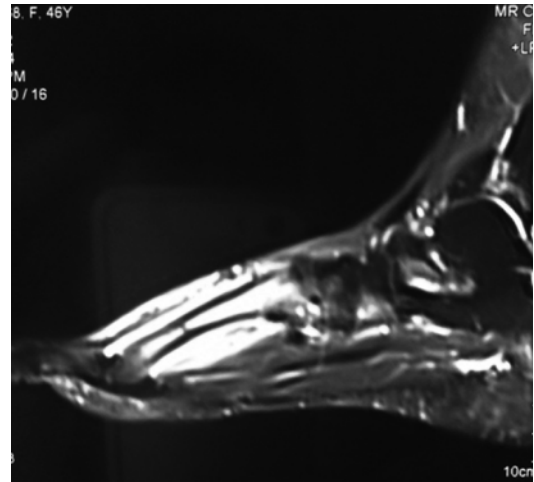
Sagittal T2 MRI image of a midshaft metatarsal stress fracture
